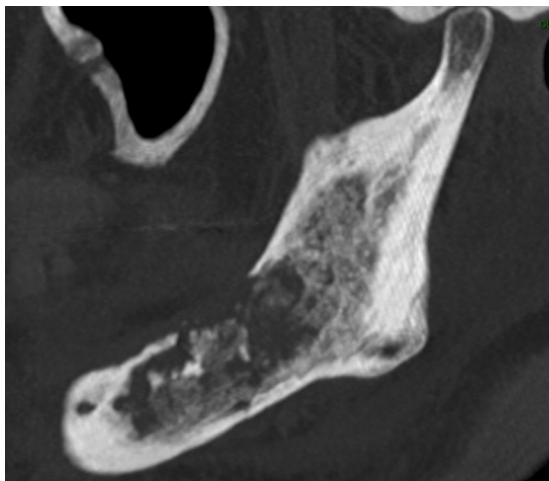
CT scan 42 months after chemoradiotherapy showing the large ORN area from the mandibular angle to the parasymphysal region with osteolysis of the superior mandibular cortical bone.
